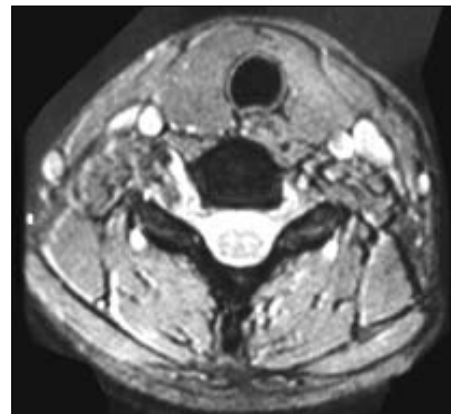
T₂ weighted axial MR image shows moderate neural foraminal widening
